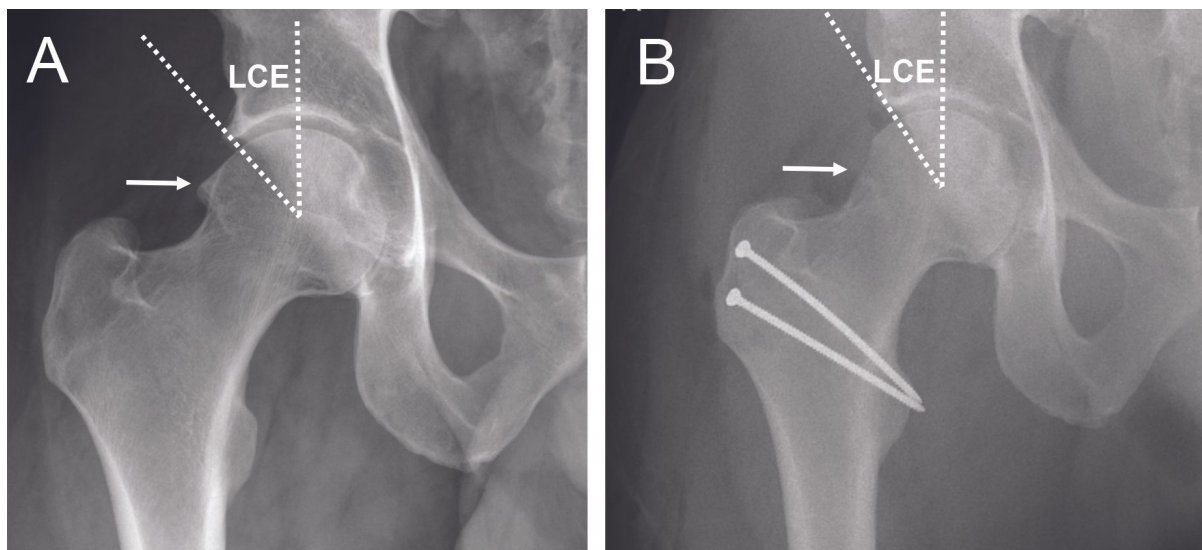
Surgical hip dislocation: imaging. On the preoperative radiograph (A) a cam effect (white arrow) and excessive coverage angle (LCE angle) can be seen. On the postoperative radiograph (B), the correction of the cam (white arrow), the correction of the coverage angle (LCE angle), and the presence of two screws to stabilize the osteotomy can be seen
